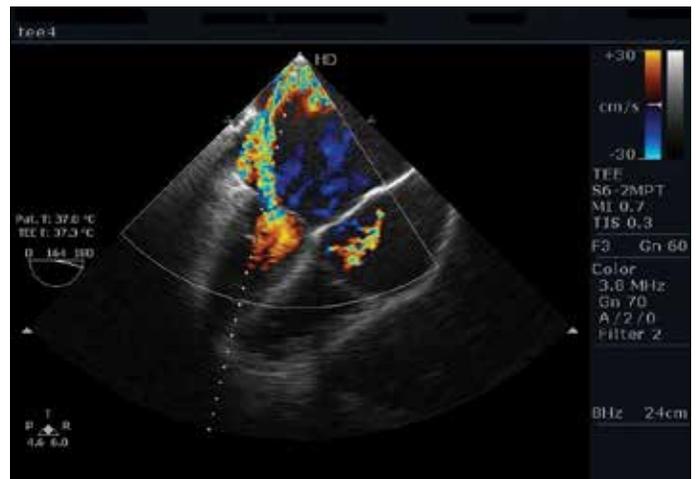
Transesophageal echocardiography view of the severe dilated left atrium and jet flow beginning from posterior mitral leaflet toward the septum
